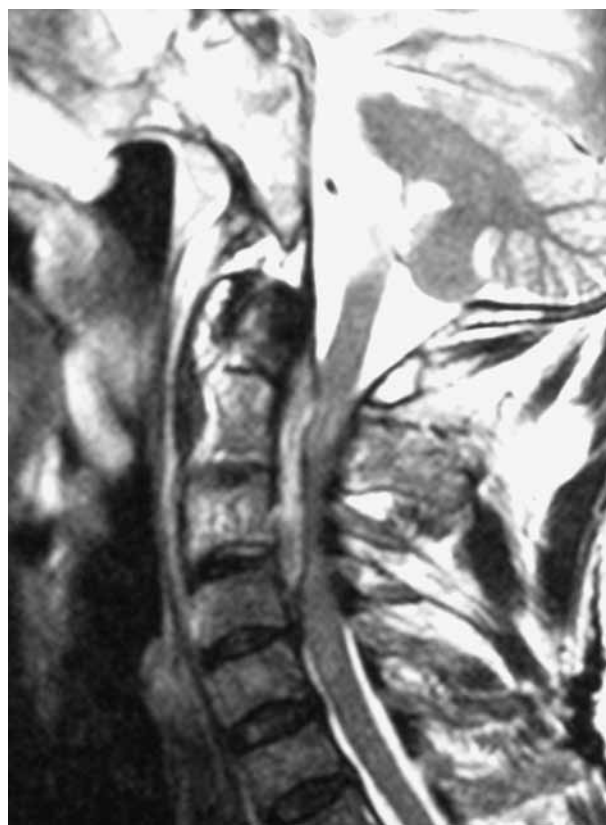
Cervical sagittal T2-weighted MRI-scan at the time of admission, revealing an anterior epidural collection C1-C4. Note the high signal intensity of the cord.
